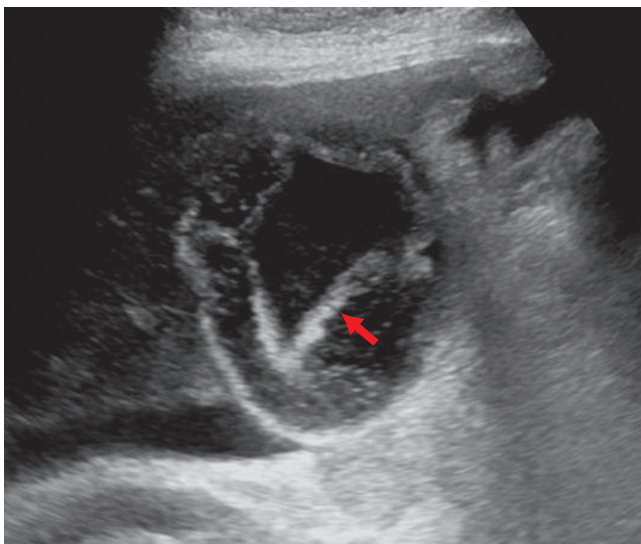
The transverse sonographic image of the gallbladder shows intraluminal membranes (arrow) consistent with sloughed mucosa.
